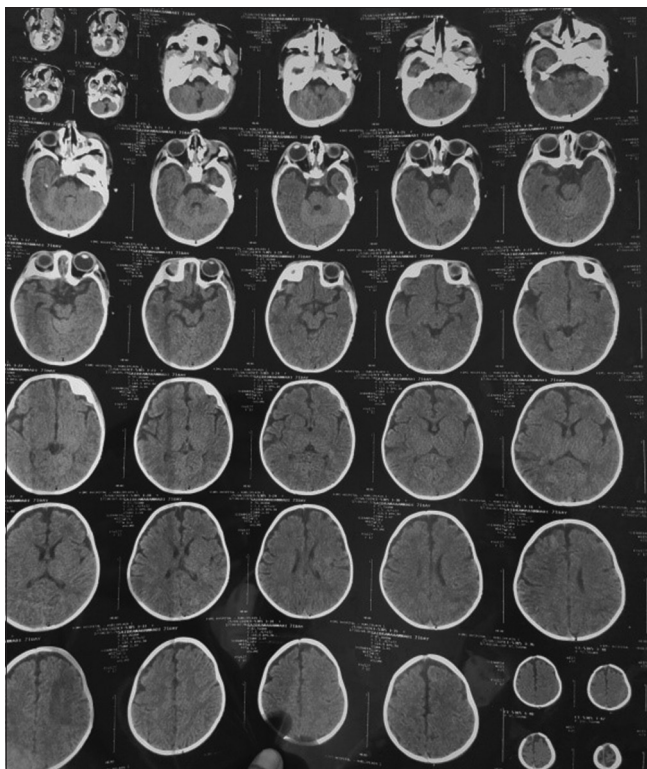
CT brain of the infant showing no significant neuroparenchymal abnormality.
